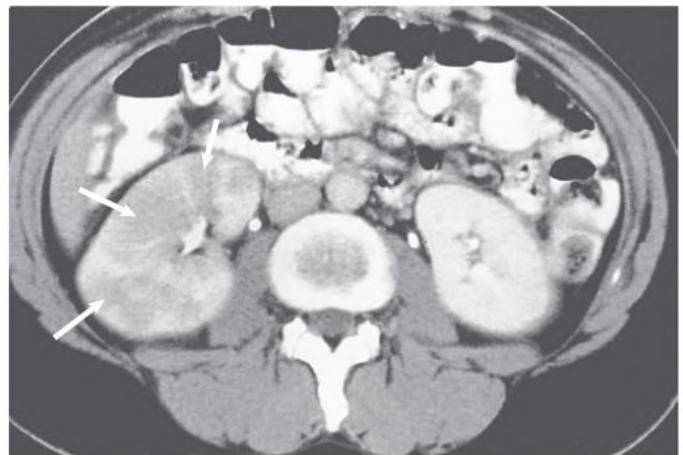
Acute Pyelonephritis. Contrast-enhanced computed tomography scan shows areas of lower density caused by infection and edema (arrows). (Courtesy W. Bush, University of Washington, Seattle.)
